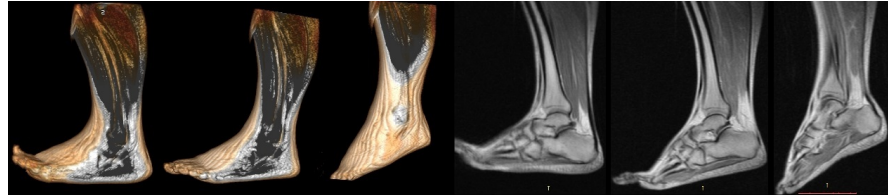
MTU length comparison for 2 consecutive days (10 trials) and MRI results (black series) for PB and PL.
